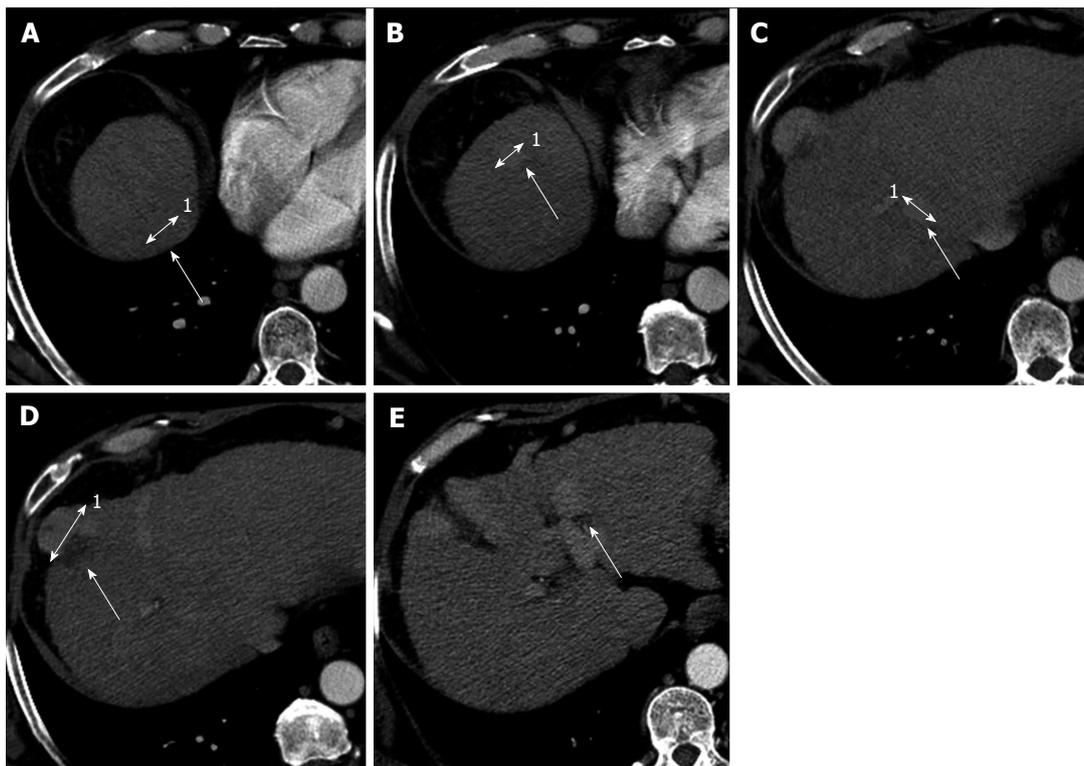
Contrast enhanced computed tomography in patient with multinodular hepatocellular carcinoma before the degradable starch microspheres transcatheter arterial chemoembolization not in agreement with new-Milan-criteria. The enhanced computed tomography images show 5 hypervascular lesions, in the patients with a score of 8 using the new-Milan-criteria. A: Hepatocellular carcinoma (HCC) on VII segment with maximum diameter of 14 mm¹; B: HCC on VIII segment with maximum diameter of 10 mm¹; C: HCC on VII segment with maximum diameter of 12 mm¹; D: HCC on VIII segment with maximum diameter of 31 mm¹; E: HCC on IV-II segment with maximum diameter of 14 mm.
